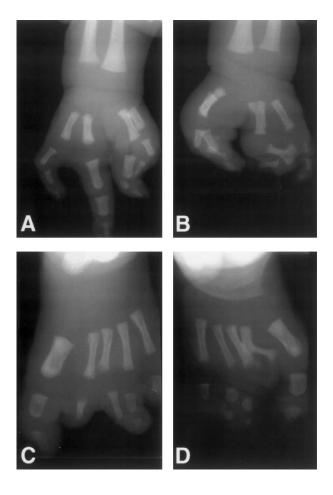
Radiographs of hand and feet of VIII:4, taken shortly after birth. For comparison with this individual's present condition, see fig. 3C and D. A, Right hand, showing normal 4th ray, absent 3d ray, and hypoplasia of the other three rays, with soft-tissue syndactyly of the 1st and 2d fingers. B, Left hand, showing absent 3d ray, superimposed 1st and 2d metacarpalia with incomplete phalanges, broad and possibly synostotic 4th metacarpus with bizarre synostotic phalanx, and soft-tissue syndactyly of the 1st and 2d fingers and of the 4th and 5th fingers. C, Left foot, showing normal metatarsalia except for the short 3d metatarsus, abnormally shaped and missing phalanges, and cutaneous syndactyly of the 3d and 4th toes. D, Right foot, showing hooked and possibly synostotic 2d metatarsus, abnormally shaped and missing phalanges, absence of the 2d toe, and cutaneous syndactyly of the 3d and 4th toes.
